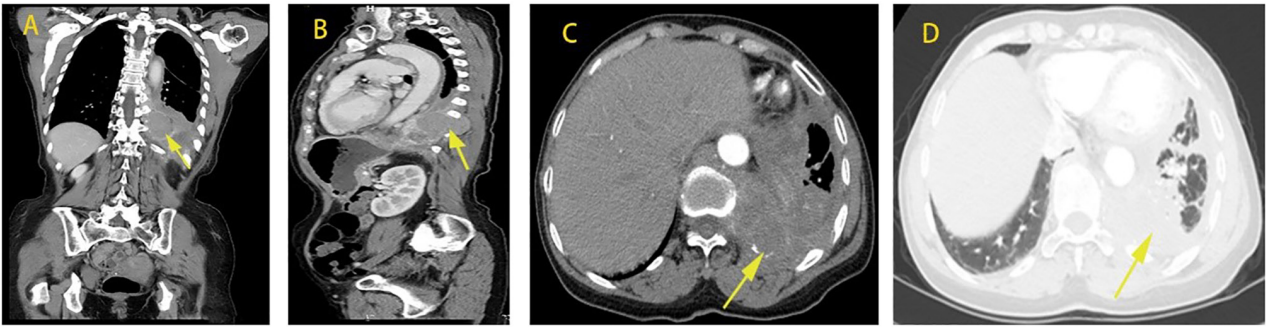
Case 3. Chest and abdominal CT in early January 2012. (A) Coronal view: A mass (the yellow arrow) is visible near the spine in the left lower thoracic cavity. The capsule is clear, but the diaphragm is not penetrated, accompanied by a small amount of pleural effusion in the left thoracic cavity. (B) Sagittal view: A mass may be observed in the left thoracic cavity, breaking through the posterior pleural cavity with a small amount of pleural effusion. (C) A mass is present near the spine of the left thoracic cavity, which breaks through the posterior pleural cavity, accompanied by left pleural effusion, and a patchy and cable-like exudative shadow of the left lung is present. (D) The enhancement of the left thoracic mass was not obvious.
